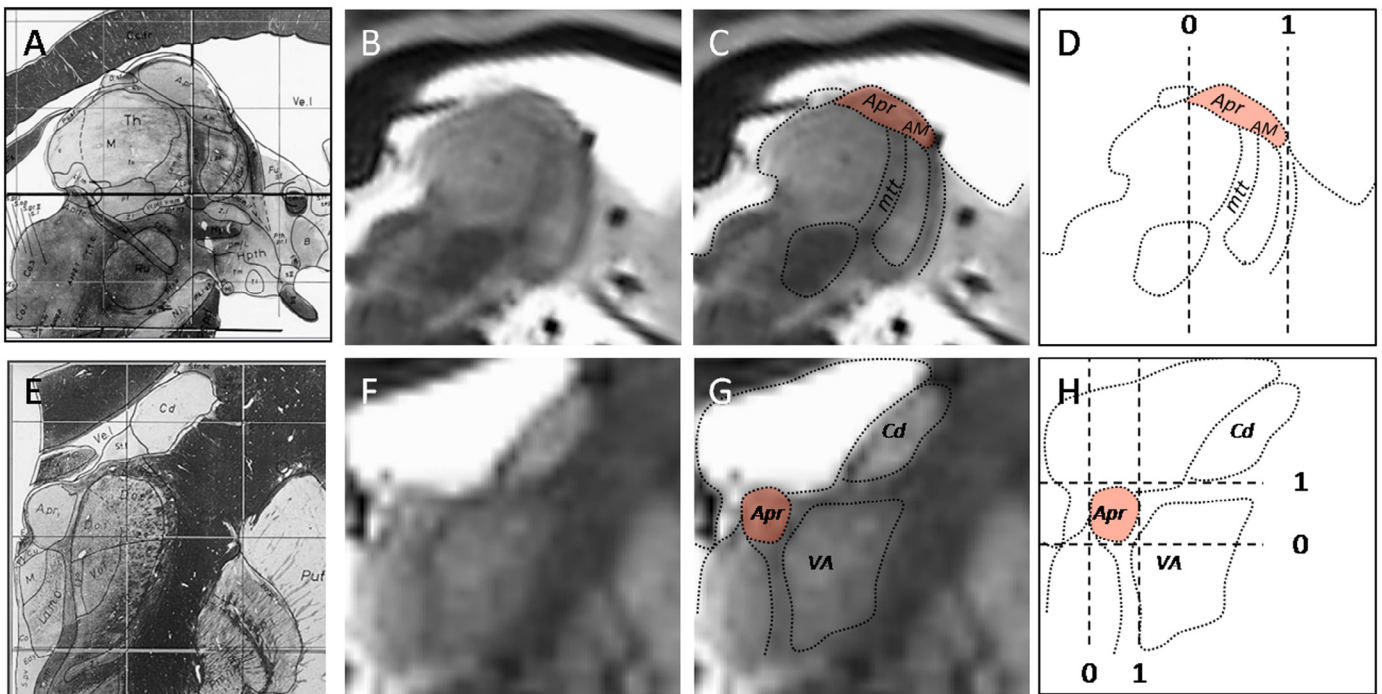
The principle of ANT normalized coordinate system. ANT normalized coordinate system is based on direct visualization of ANT in 3T STIR images. Sagittal (A) and coronal (E) images from SWA are shown for comparison with 3T MRI STIR images (B–C, F–G). In ANT-normalized coordinate system the most posterior border of ANT is defined as 0 and most anterior border as 1 (D). The medial and inferior borders are defined as 0 and the lateral and superior border as 1 in coronal image through the mamillo-thalamic tract where ANT is most reliably visualized (H). The anterior–posterior axis of ANT-normalized coordinate system is oriented along AC–PC line and both medial–lateral axis and inferior–superior axis are perpendicular to AC–PC line. Abbreviations: Apr, anterior principal nucleus; AM, anteromedial nucleus; VA, ventral anterior nucleus; Cd, nucleus caudatus; mtt, mamillo-thalamic tract, SWA, Schaltenbrandt–Wahren atlas. Printed with permission.
